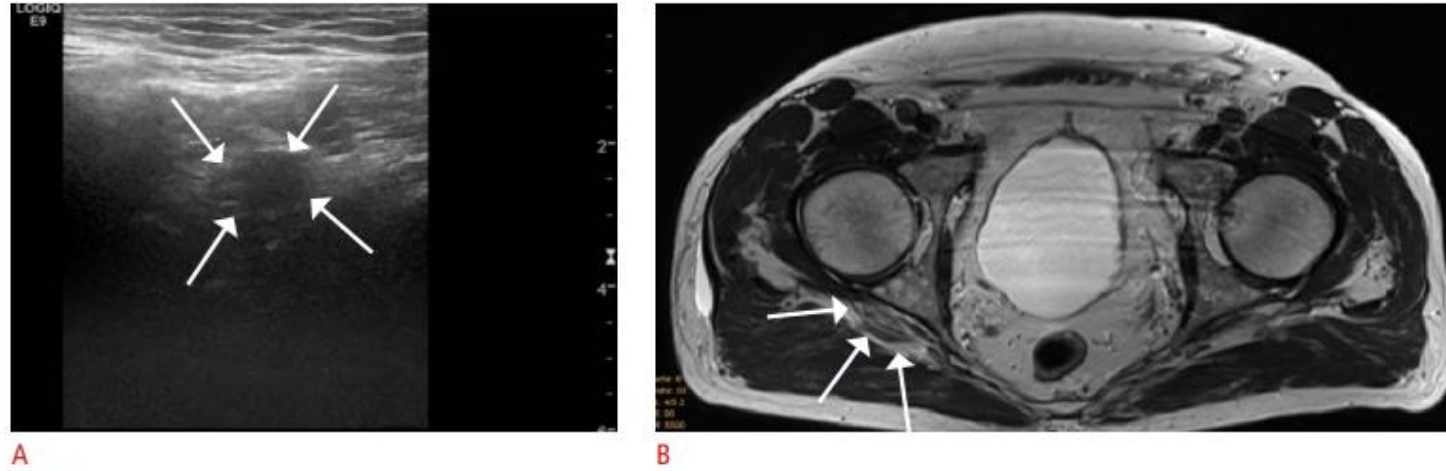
A 67-year-old patient presenting with sciatica, who underwent previous magnetic resonance imaging of the spine to rule out affection of the nerve roots.
